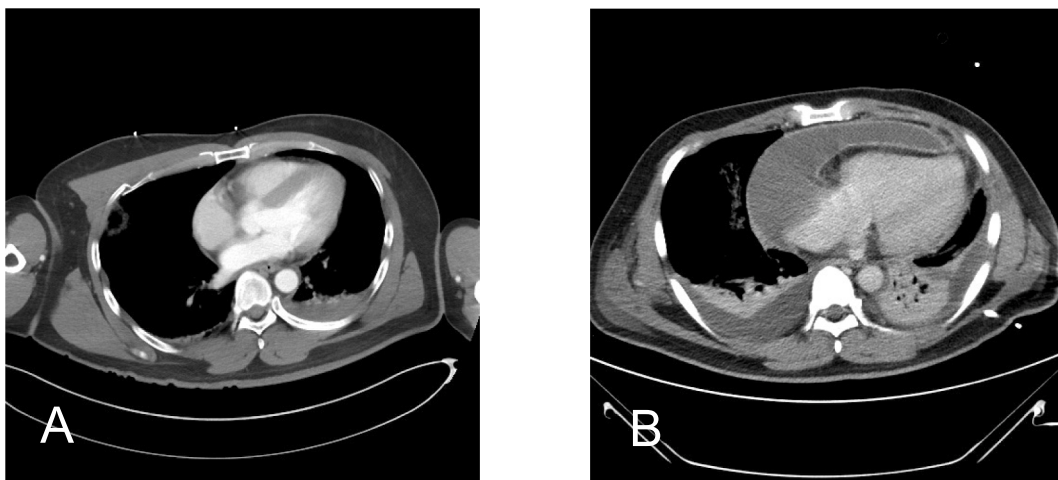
Axial slices of CT. A) Initial ER CT; no fluid located at the pericardium. B) Severe purulent pericardial effusion at the right heart border, suggestive of purulent pericarditis with cardiac tamponade.
